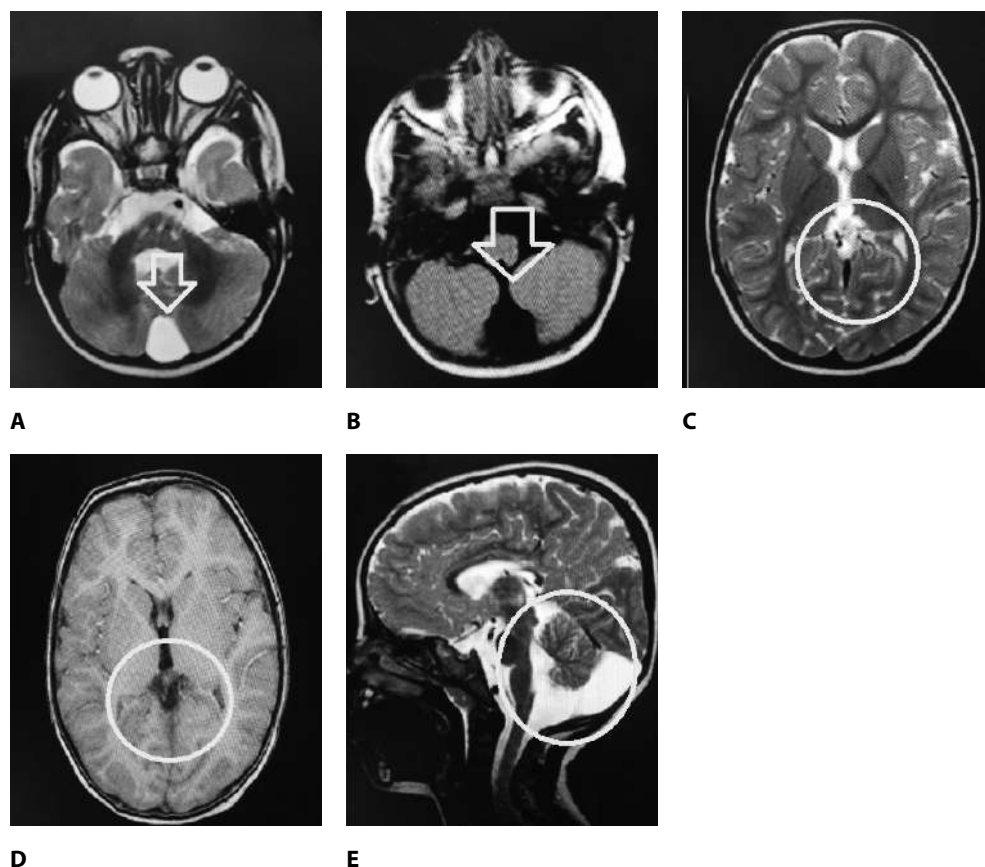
28 months new baby (Mega cisterna magna): A. T2WI axial: large retro-cerebellar space that follow the CSF signal intensity and no vermian anomaly. B. FLAIR axial: large retro-cerebellar CSF space with fluid signal drop. C. T2WI axial: normal white and gray matter with normal lateral and 3rd ventricles. D. T1 axial: normal gray and white matter and ventricular system. E. T2WI sagittal: enlargement of CSF fluid in posterior fossa and seen in communication of rest of subarachnoid spaces
